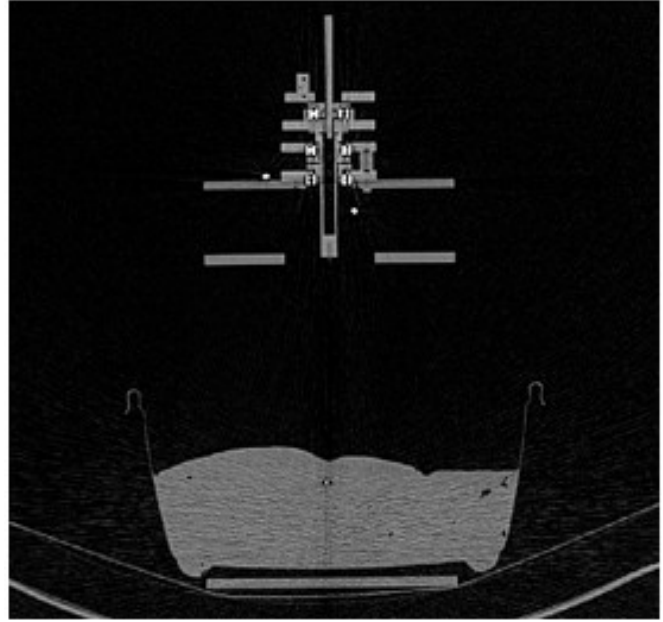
Cross-sectional CT image of the steerable needle robot with stylet inserted in ex vivo liver tissue.
